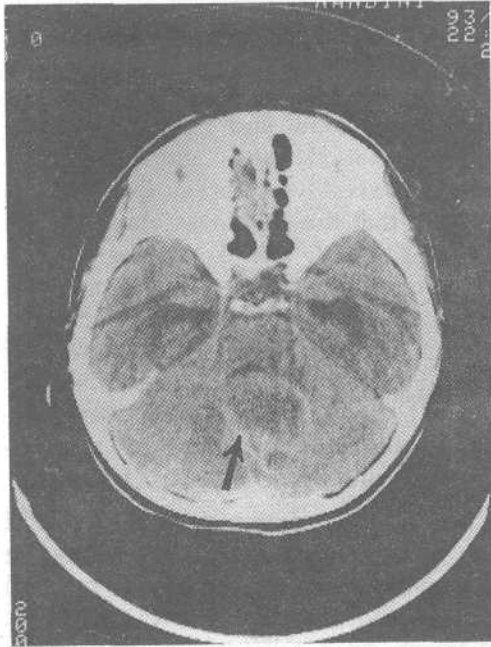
Contrast CT scan showing multiple hypodense lesions in the posterior fossa with ring enhancement.
